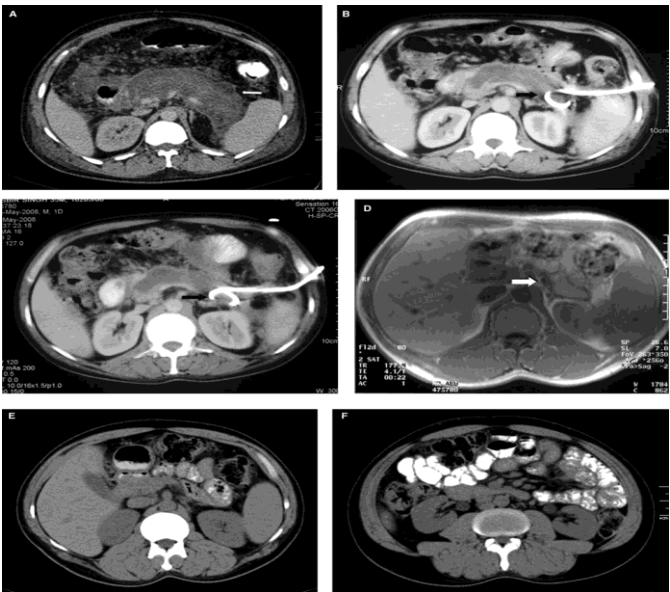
A, CECT abdomen (day 10 after the onset of pancreatitis) showing near-complete necrosis of the pancreas. B, CECT abdomen (day 43 after the onset of pancreatitis) showing PCD in the body and tail region of the pancreas; PCD insertion done on day 18 of the disease. C, CECT abdomen (day 58 after the onset of pancreatitis) showing PCD in the body and tail region of the pancreas with residual collection. D, MRI abdomen T1-weighted axial image (day 870 after the onset of pancreatitis) showing normal pancreatic tissue in the body and tail region. E, Follow-up CT scan at day 1408 after the onset of pancreatitis showing atrophy of the body and tail region of the pancreas. F, Follow-up CT scan at day 1408 after the onset of pancreatitis; the axial section at a level inferior to the pancreas shows complete resolution of the necrosis.
